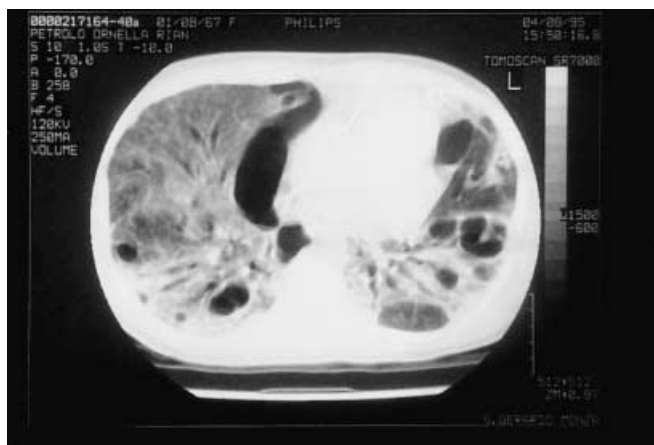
A CT scan is mandatory in very aggressive lung disease where the air collection can show an unusual distribution. In this case of staphylococcal pneumonia complicating an episode of pulmonary embolism in a 23-year-old woman, a loculate air collection deforms the right heart profile. Haemodynamic monitoring had shown high filling pressures and a low cardiac output. Percutaneous chest drainage was performed under CT guidance; opacities, air bronchograms and bullae were present on both the left and right sides
